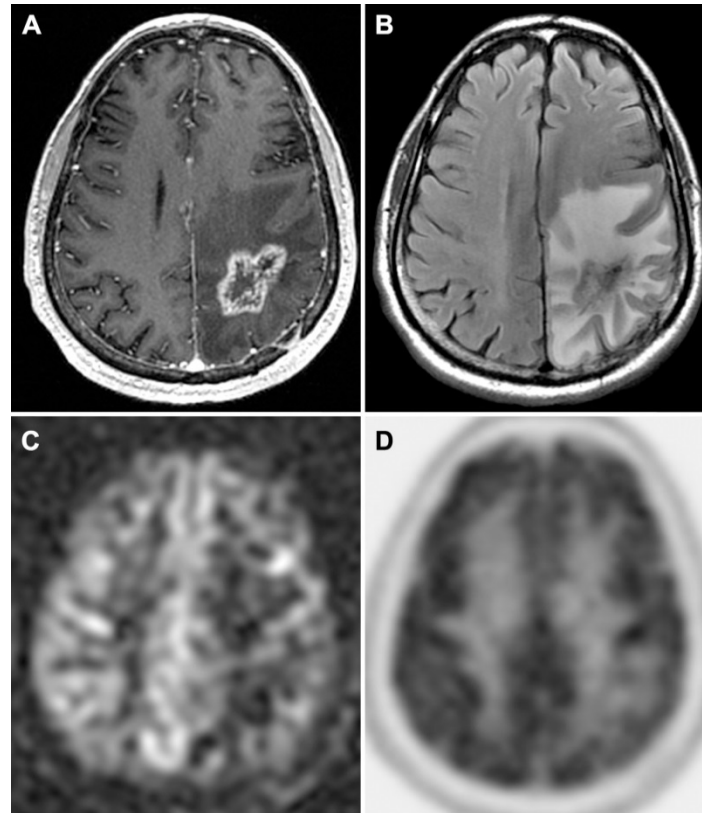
Images in 57-year-old man with lung cancer brain metastasis 15 months after resection, radiation, and chemotherapy. A, Axial T1-weighted gadolinium-enhanced image shows a new enhancing lesion, with, B, axial fluid-attenuated inversion recovery image demonstrating extensive vasogenic edema in the region of the resection cavity. C, ASLarterial spin labeling image demonstrates no increase in CBFcerebral blood flow in this region, similar to findings on, D, FDGfluorine 18 fluorodeoxyglucose PET image. These findings were considered to represent radiation necrosis and the patient is being followed serially rather than with re-resection.
